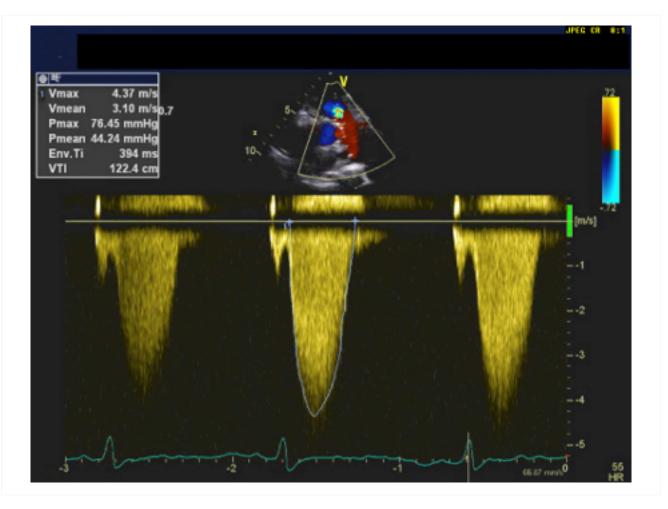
Continuous wave doppler demonstrating severe pulmonary stenosis on transthoracic echocardiogram
